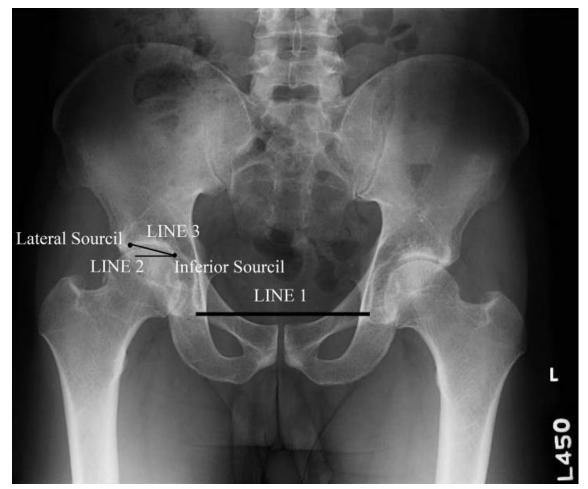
Representative technique for calculation of the Tönnis angle (JC Clohisy, A Systematic Approach to the Plain Radiographic Evaluation of the Young Adult Hip. 2008)
